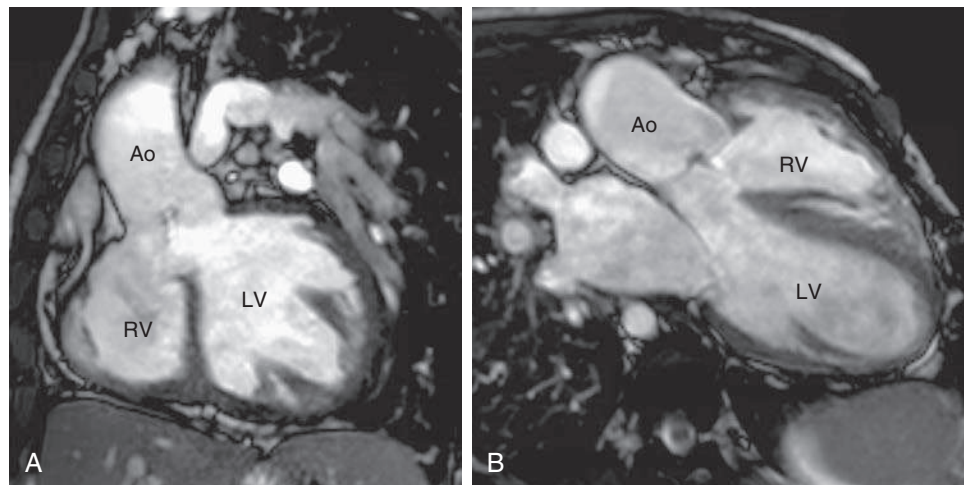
Oblique coronal magnetic resonance imaging (A) and three-chamber view (B) showing a large ventricular septal defect with the aorta overriding both the right and left ventricles. Patient was not repaired, and hence there is persistent RV hypertrophy from systemic level pressures. Ao, Aorta; RV, right ventricle.
